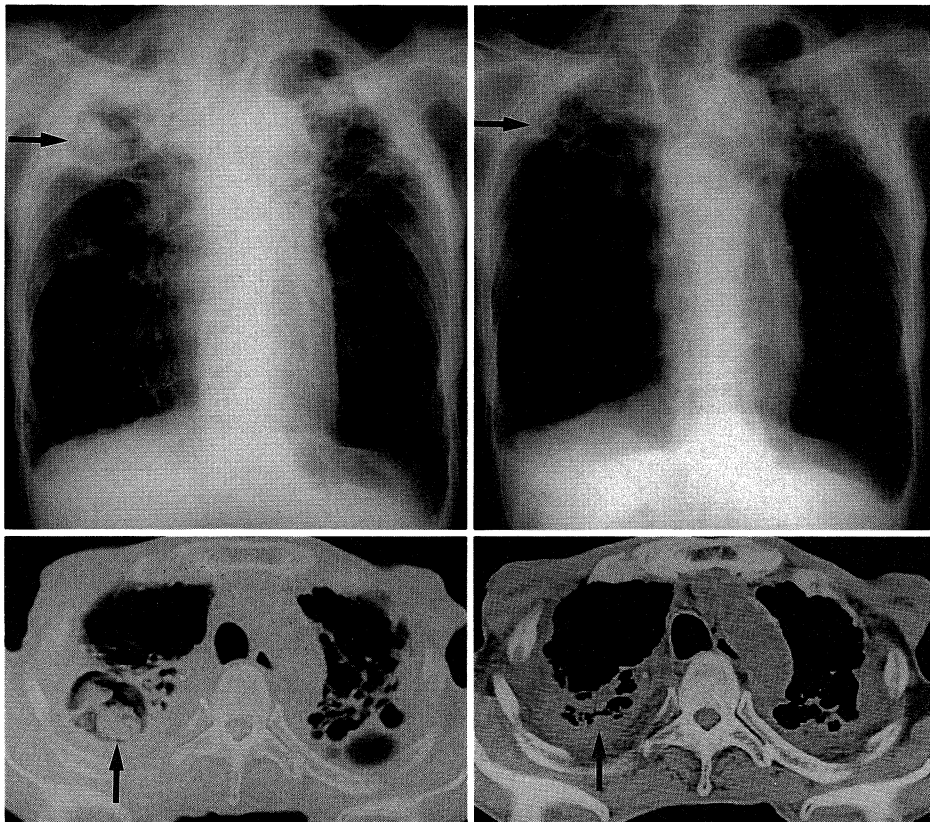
Chest X-ray films of Case 2 by frontal view (upper) and CT films (lower) before (left side) and after (right side) treatment. Fungus balls indicated by the arrows remarkably shrank after treatment with fluconazole.
